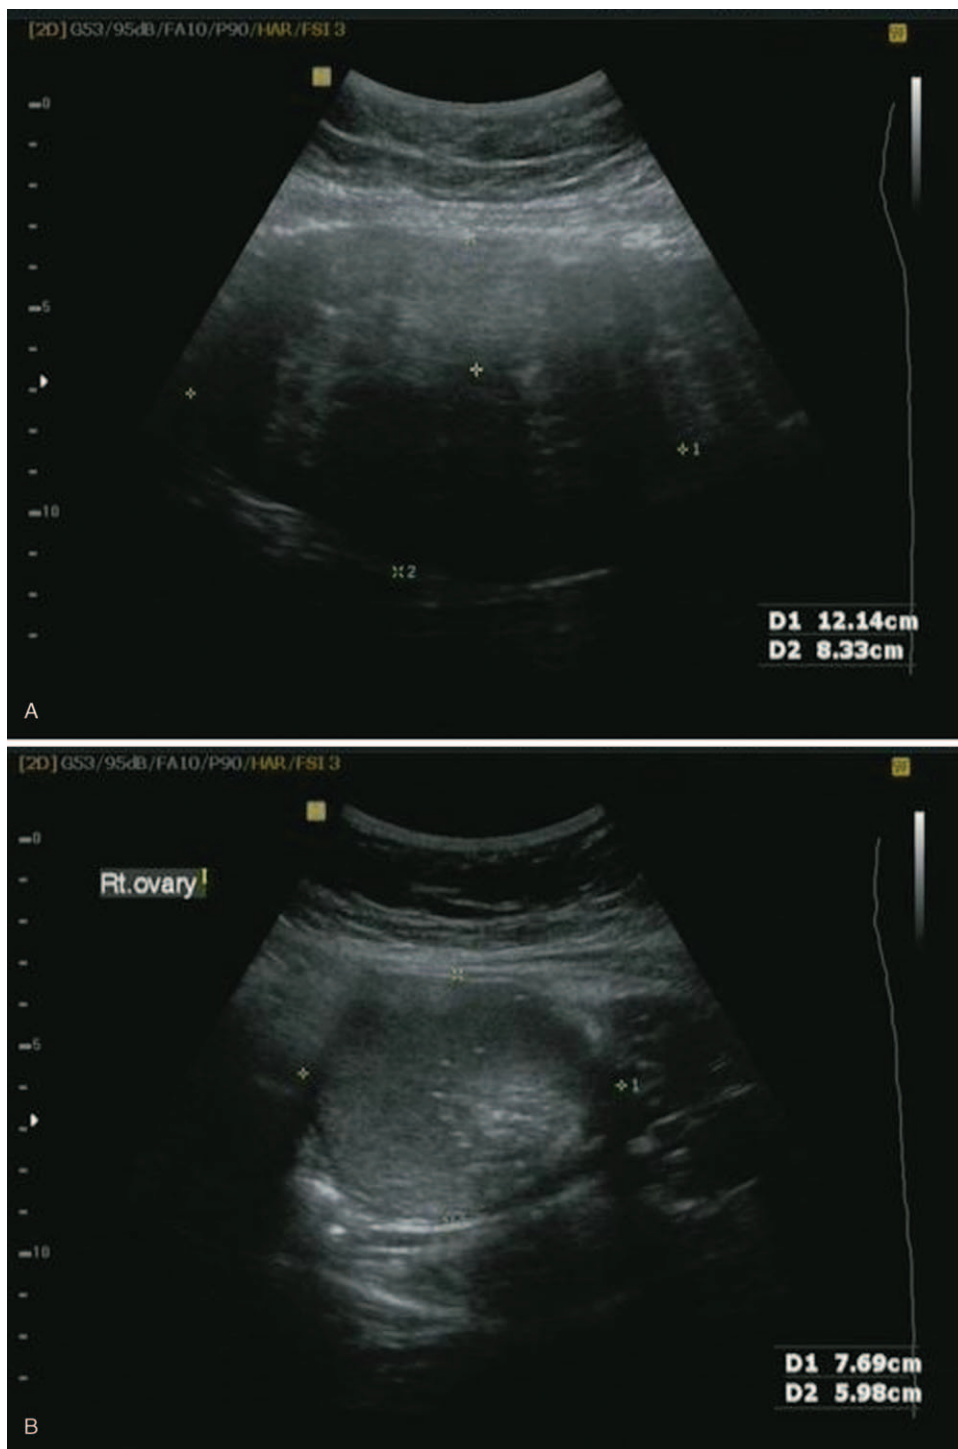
The ultrasound scan during first pregnancy showing a solid mass (12.1 × 8.3 cm) at the uterine fundus (A), and complex echogenic mass (7.7 × 6.0 cm) at the right adnexa (B) at 19 weeks of pregnancy. (C) Showing change of internal echo of uterine fibroid, suggestive degeneration at 34 weeks of pregnancy.
